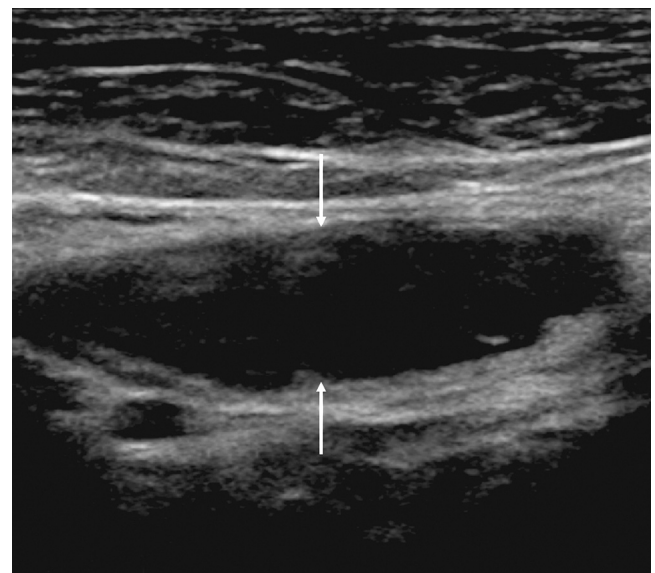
A cyst of the canal of Nuck. Oblique sonography of the left groin, demonstrating a discrete cyst (arrows) along the inguinal ligament of a female patient. This is along the course of round ligament and suggestive of a cyst of the canal of Nuck.
